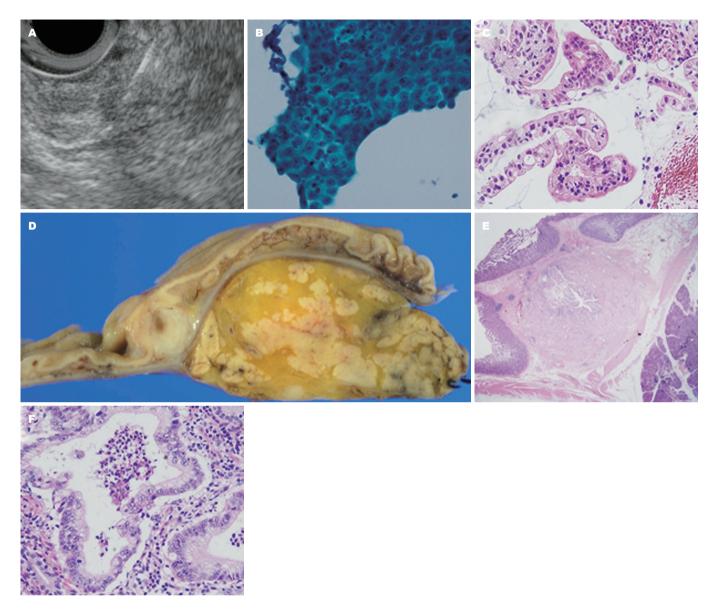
This patient underwent EUS-FNA (Fig. 3A). Endoscopic ultrasound-guided fine needle aspiration indicated malignancy (Fig. 3B, C). At a later date, this patient underwent surgical operation. Final diagnosis was intra-ampullary-type carcinoma of ampullary of Vater (Fig. 3D, E, F).
